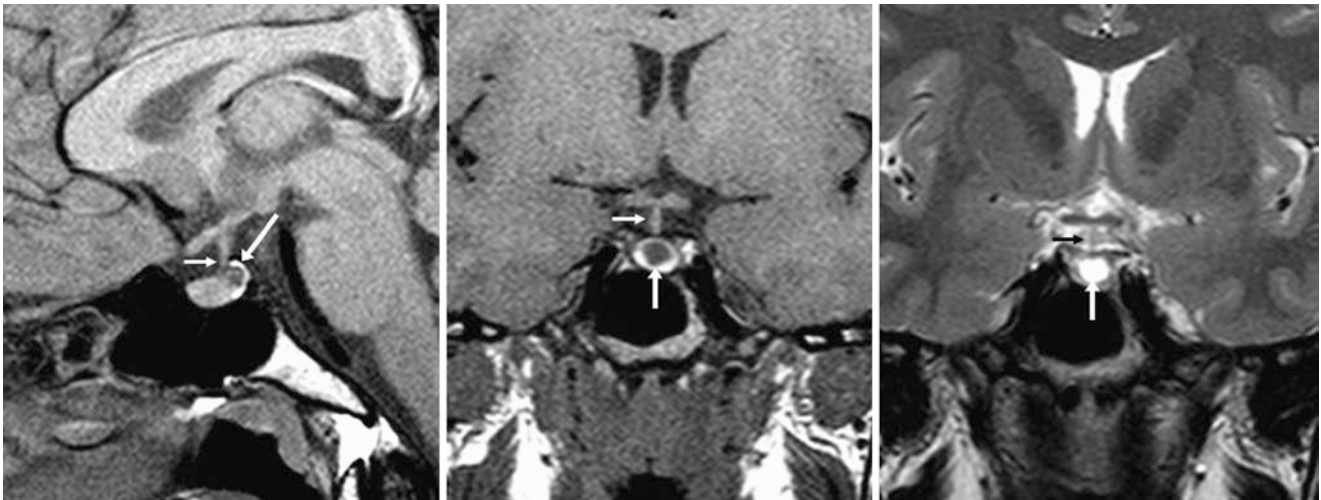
The patient was a 25-year-old female with oligomenorrhea. A 1.5 T MRI demonstrated a 4–5-mm RCC (*arrows*) located just posterior to the stalk (*thin arrows*) that appeared hypointense on noncontrast sagittal T1WI (*left*) and coronal T1WI (*middle*). The RCC is bright on coronal T2WI (*right*). The symptoms were thought to be unrelated to the RCC
